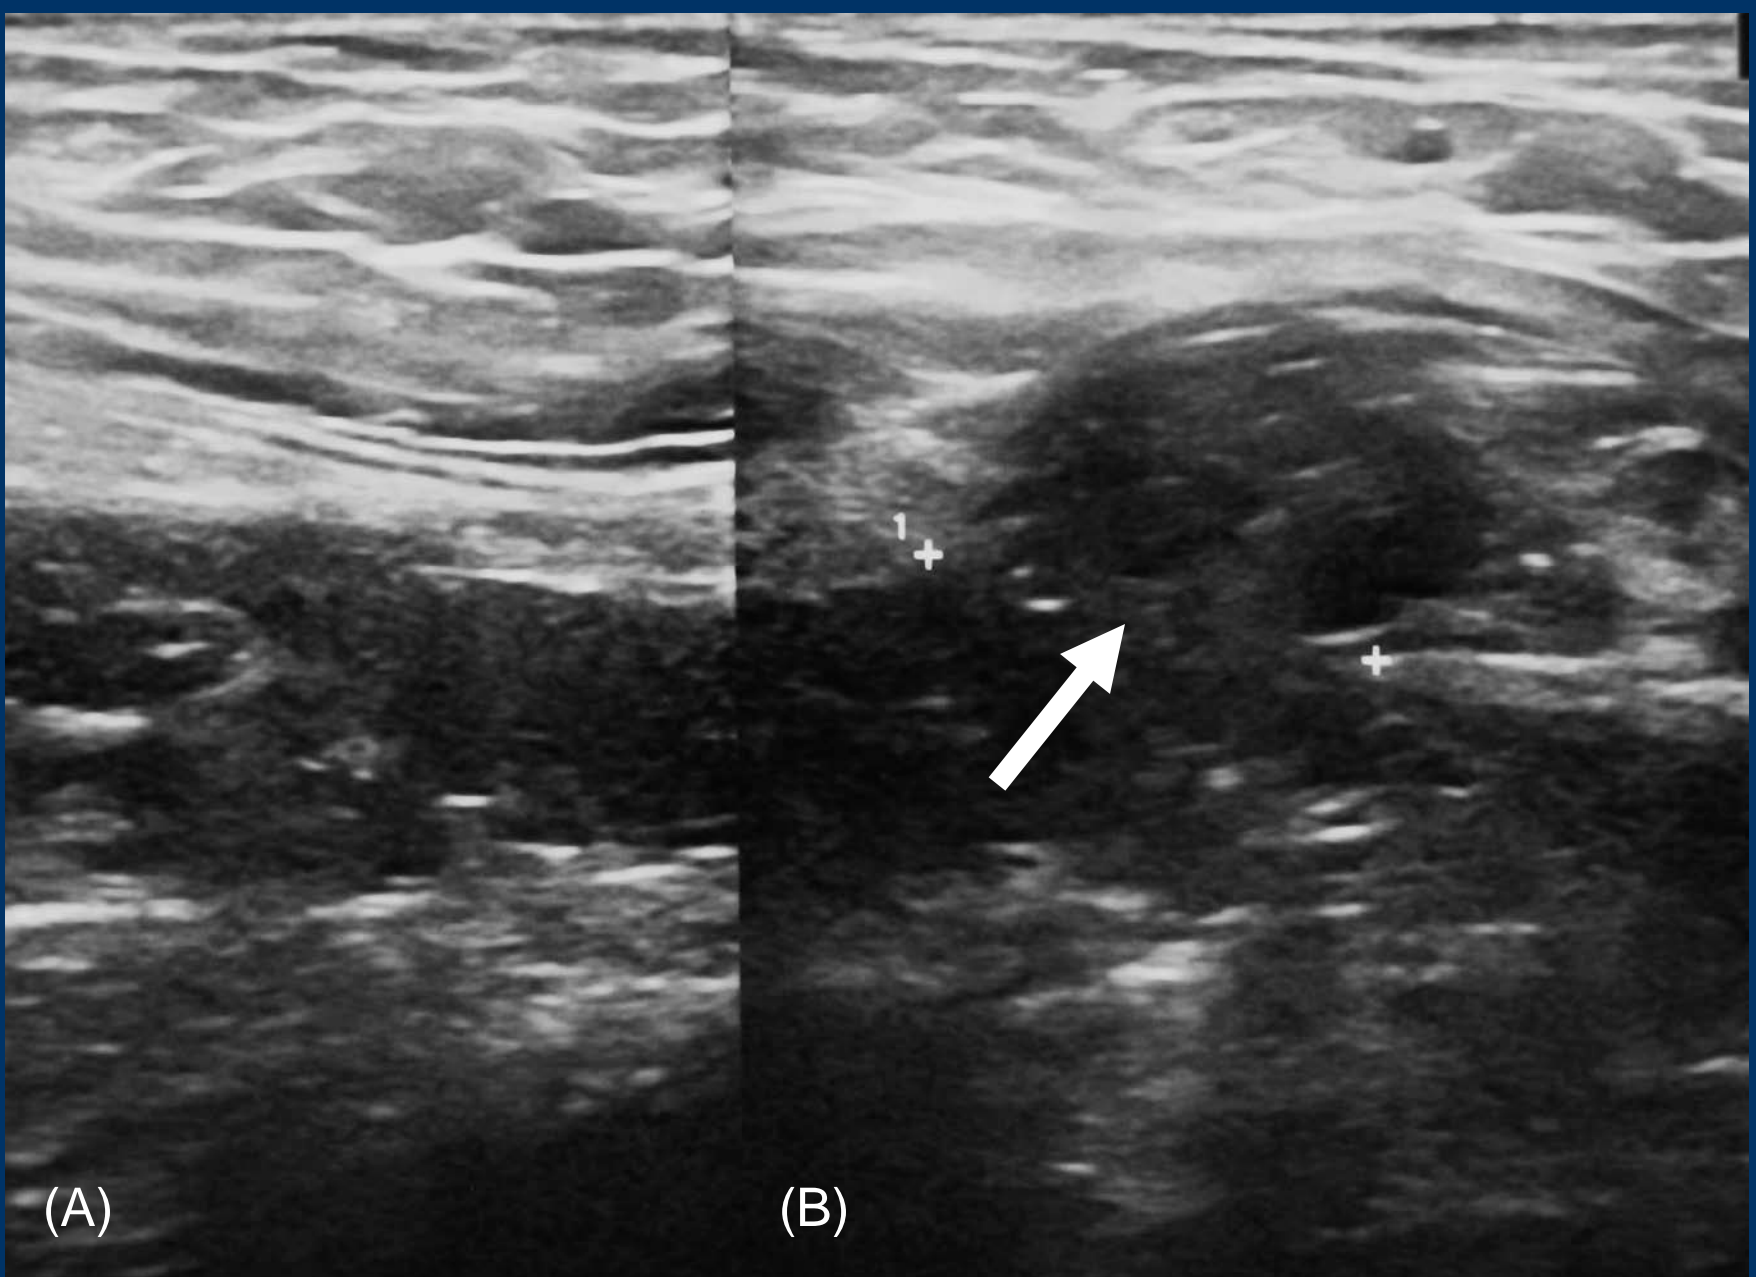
Ultrasound of a right direct inguinal hernia with the patient relaxed (A) and straining (B). (Source: M.Brygel)
